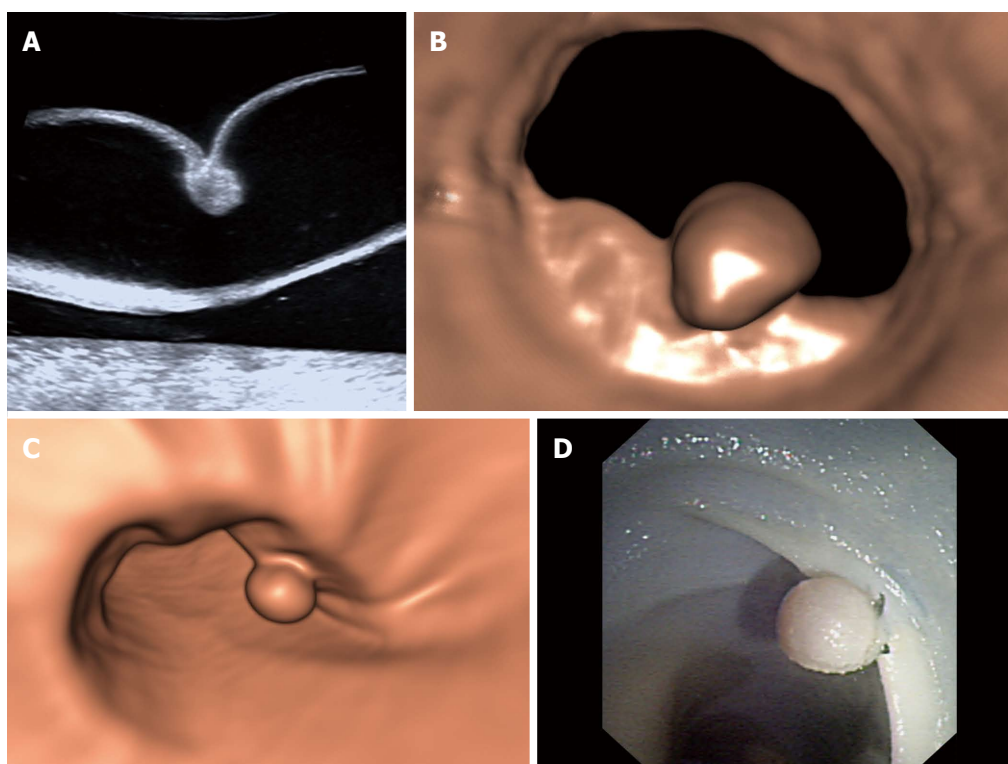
A 6-mm created polyp is clearly depicted on two-dimensional ultrasonography (A), ultrasound virtual endoscopy (B), computed tomography colonography (C) and optical colonoscopy (D).
